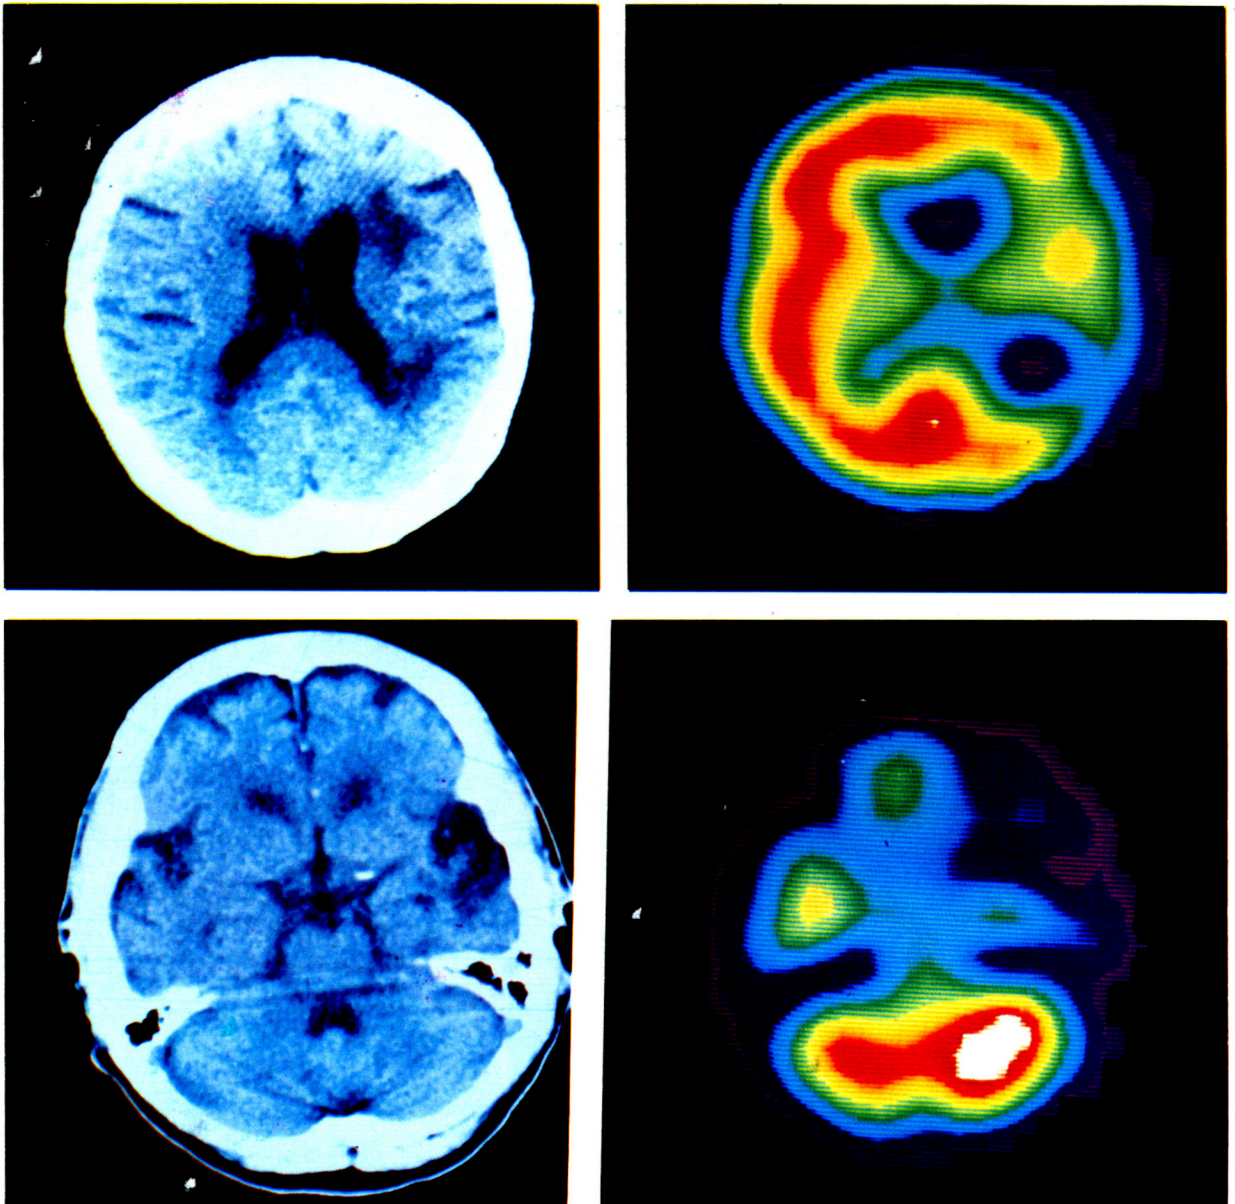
Crossed cerebellar diaschisis. Cerebral infarction in the left cerebral hemisphere was seen on CT (upper left), while the SPECT image had a larger area of decreased perfusion in the same region (upper right). A decreased uptake in the contralateral cerebellar hemisphere (lower right) was evident despite no cerebellar lesion on CT (lower left).
